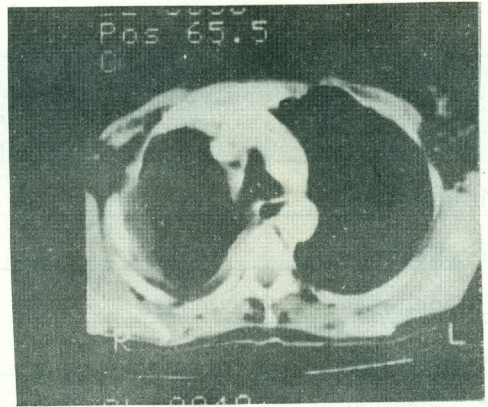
CT-scan of a case with malignant pleural mesothelioma showing LT. pleural thickening and lung encasement.
